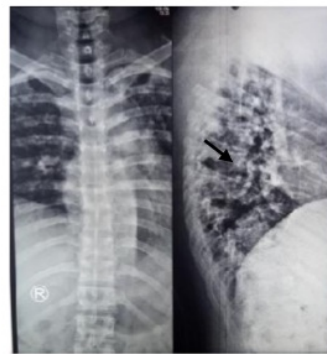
The AP/lateral thoracolumbar X-ray shown that paravertebral soft tissue mass at the left side T5-T10 levels.
